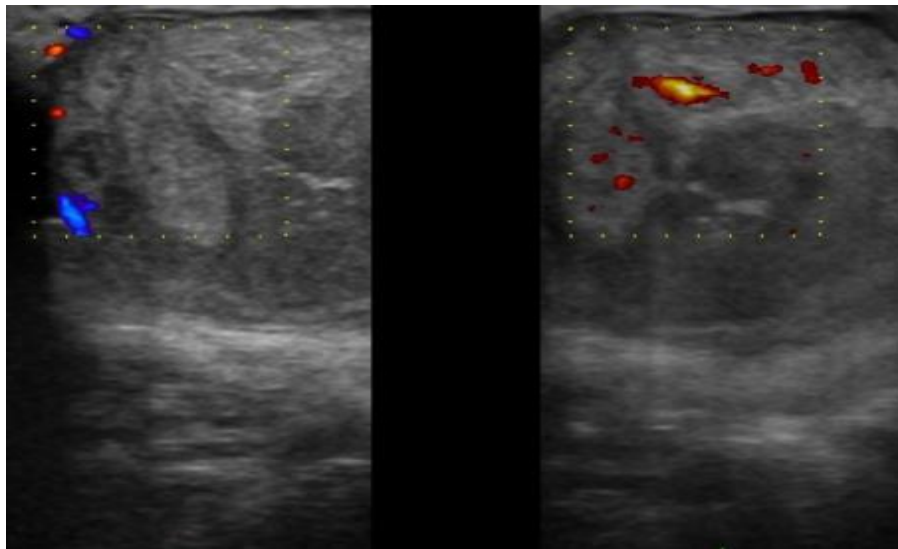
4 On Doppler, the lesion does not show significant arterial flow. However, on compression, augmentation of venous flow is noted
